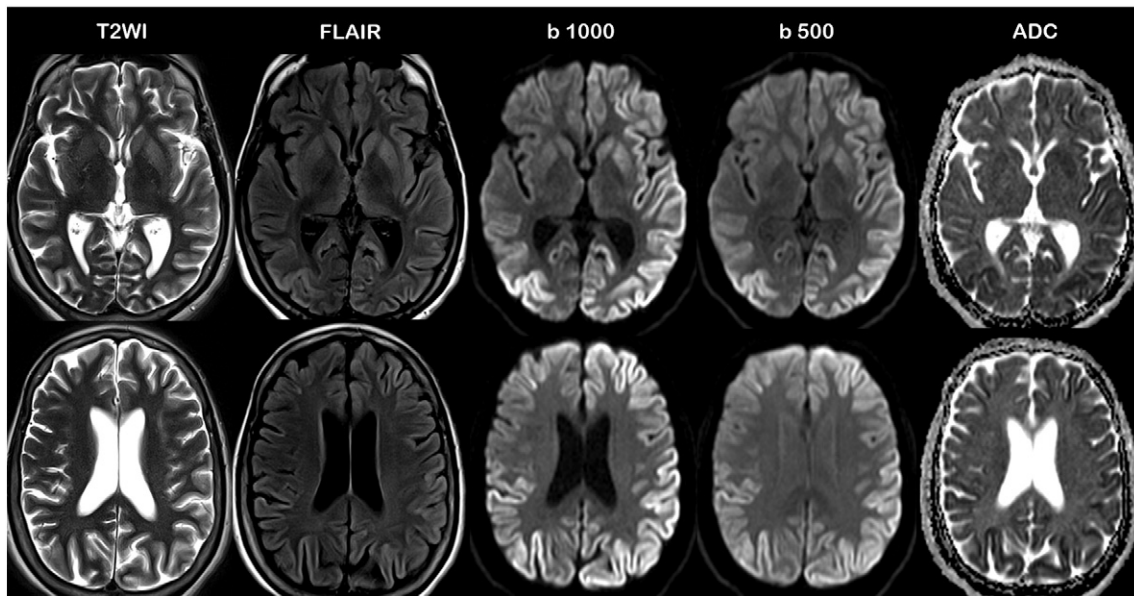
MR images used for clinical diagnosis of sCJD in one patient with sCJD acquired at the level of the basal nuclei and lateral ventricles. Affected (CJD+) regions look bright and are more prominent on DWI with $b = 1000$ than $b = 500$, FLAIR and T2WI respectively in this order. Affected regions with decreased diffusivity look darker on ADC maps. Note the asymmetry of signal hyperintensities that in this patient are more extensive in the left cerebral hemisphere than in the right, basal nuclei and thalami.
